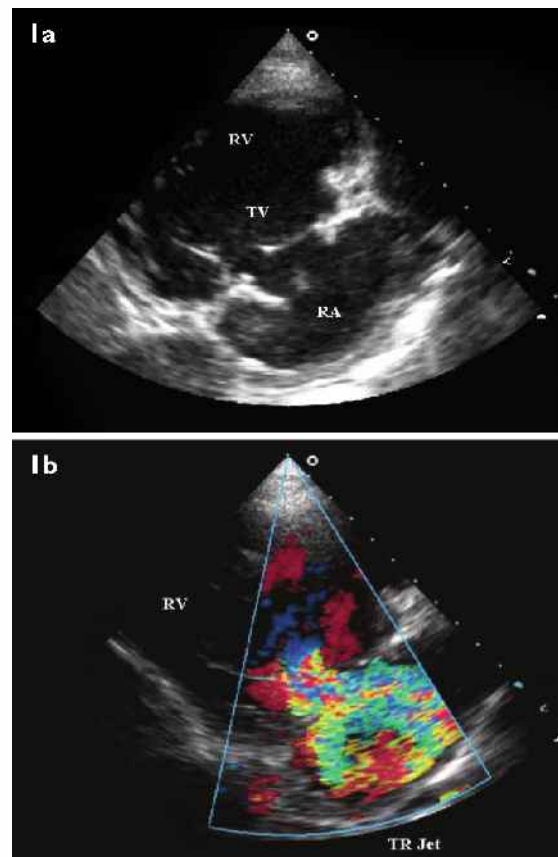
Echocardiograms (parasternal long axis right ventricular inflow view) show (a) vegetations adhered to the tricuspid valve leaflets, causing malcoaptation of the leaflets at systole, and (b) severe tricuspid regurgitation.
